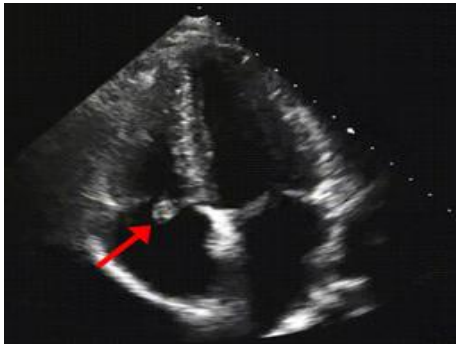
Apical 4-chamber view showing a large tricuspid valve vegetation
